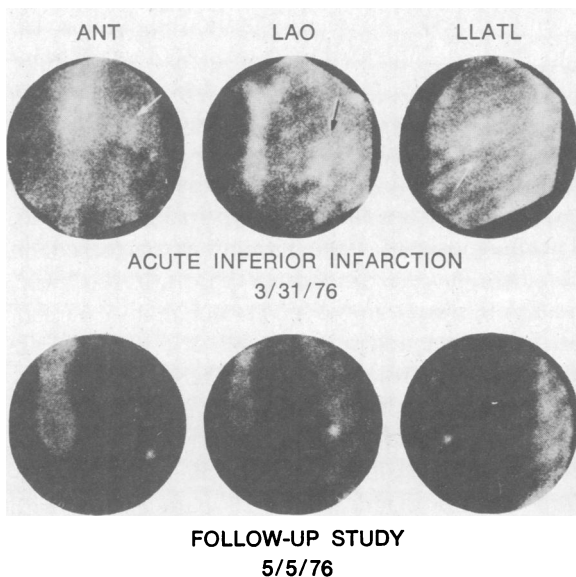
Remote infarction. Above (upper panel) are the TcPYP scintigrams in the anterior (ANT), left anterior (LAO) and left lateral (LLATL) projections done at the time of acute inferior infarction. The scintigram is abnormal with a 3+ discrete inferior accumulation (arrows). In the lower panel are the scintigrams done in the same patient five weeks later. The patient was asymptomatic at the time of follow-up study and the image was normal with the exception of a persistent punctate rib abnormality.
